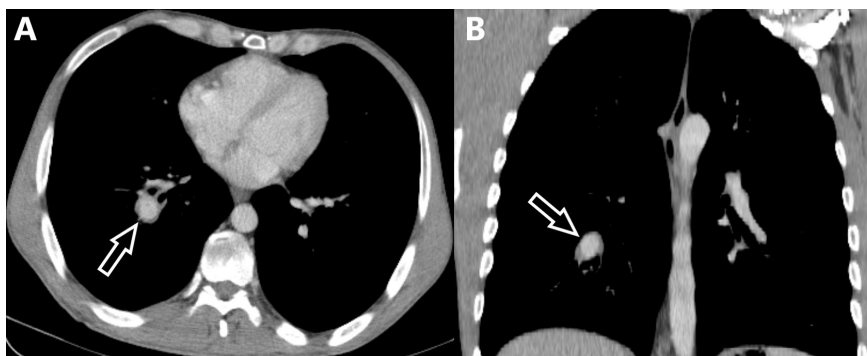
A solitary peripheral pulmonary aneurysm in the lower lobe of the right lung is observed in contrast-enhanced axial (A) and coronal (B) thorax CT in a 39-year-old male patient with a diagnosis of Behçet's disease.
